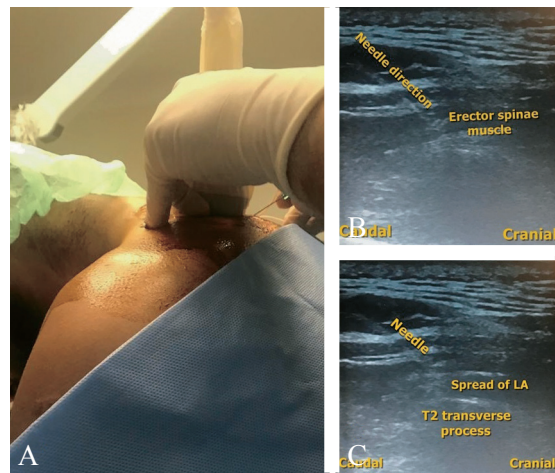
A) Block performing under aseptic conditions at the T₂ vertebral level with in plane technique. A 22-gauge 50-mm block needle was inserted in a caudad to cephalad direction; B) sonographic anatomy and needle direction; C) spread of local anesthetic.
